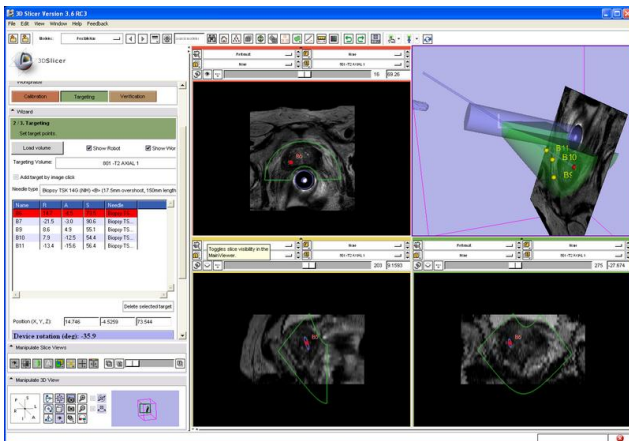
Screenshot of the planning and targeting software used for MRI-guided prostate biopsy
